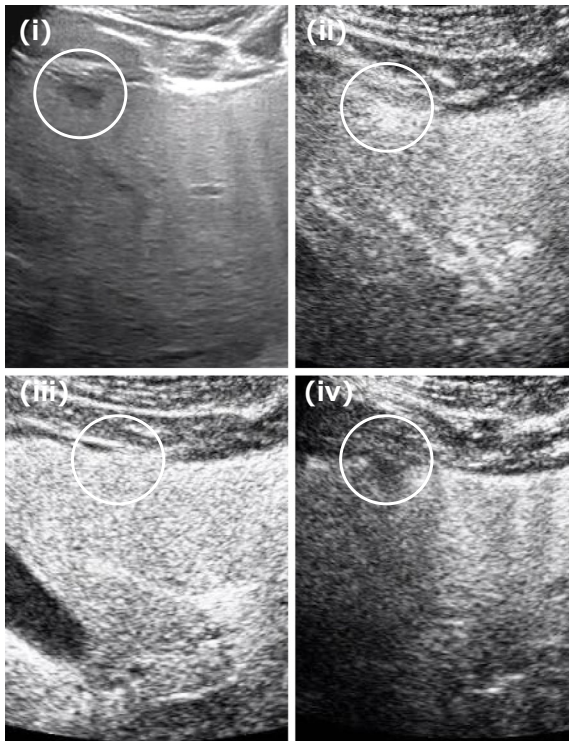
B-mode ultrasonography (US) showed an 8-mm hypoechoic space-occupying lesion in S4 (i). On contrast-enhanced US with sonazoid, the space-occupying lesion showed hyper-enhancement in the early vascular phase (ii), prolonged enhancement in the late vascular phase (iii), and defect in the Kupffer phase (iv).
